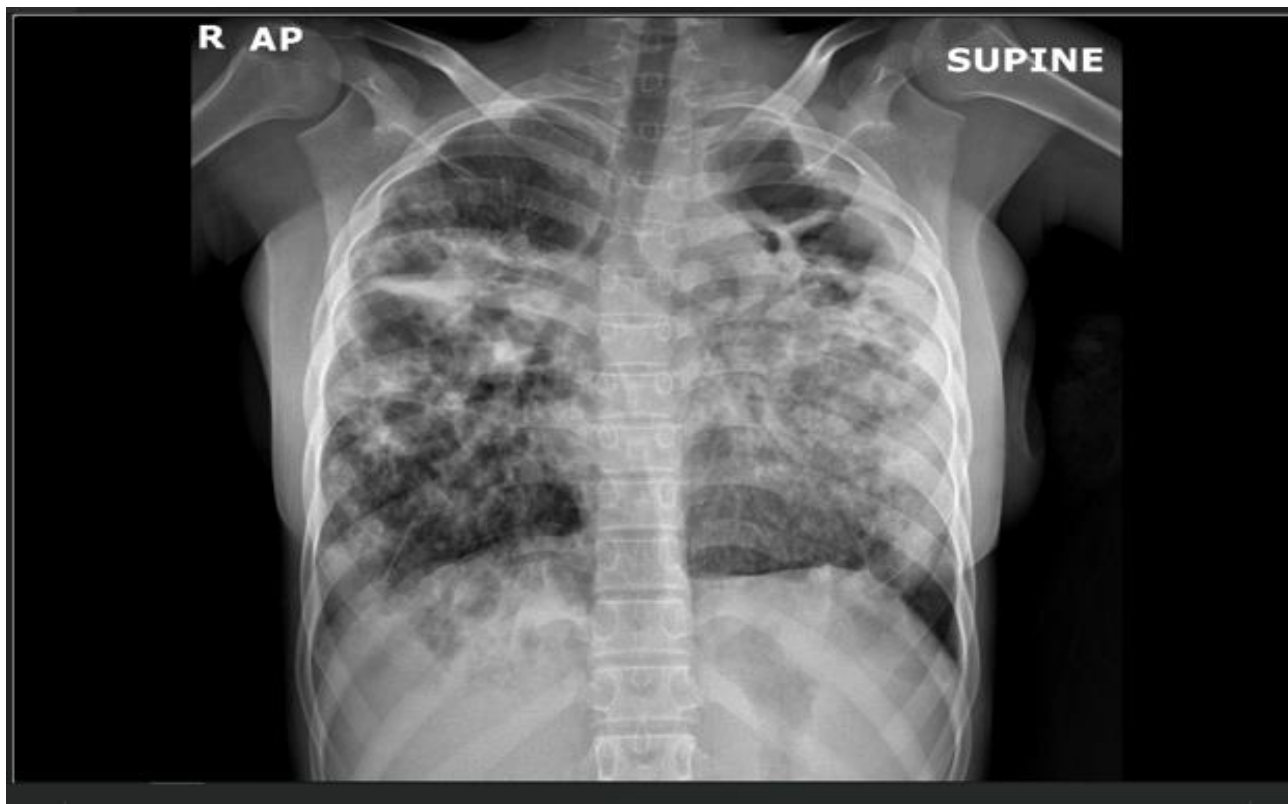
Chest X-rays of a 17-year-old girl with pulmonary tuberculosis showing thick walled cavitory lesions, two on the right upper and middle lung zones and one on the left upper lung zone associated with bilateral multiple air space opacities more on the upper, middle and lower lung zones sparing the apical zones bilaterally suggestive of pulmonary tuberculosis
